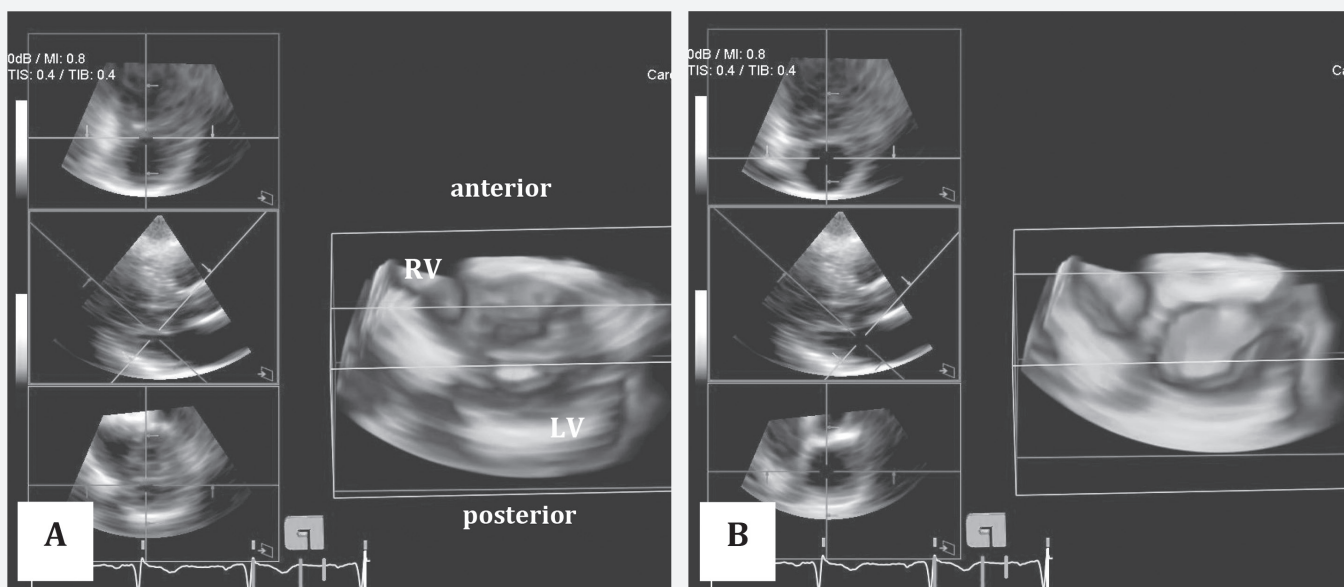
Transthoracic 3D echocardiography en-face view of the mitral valve apparatus from left ventricular perspective demonstrating presence of intervening tissue at the mid- to apical portions (A) and its absence at the basal portion (B) of the mitral valve, suggesting an “incomplete bridge type” of double-orifice mitral valve. Abbreviations: 3D, three-dimensional; LV, left ventricle; RV, right ventricle.
